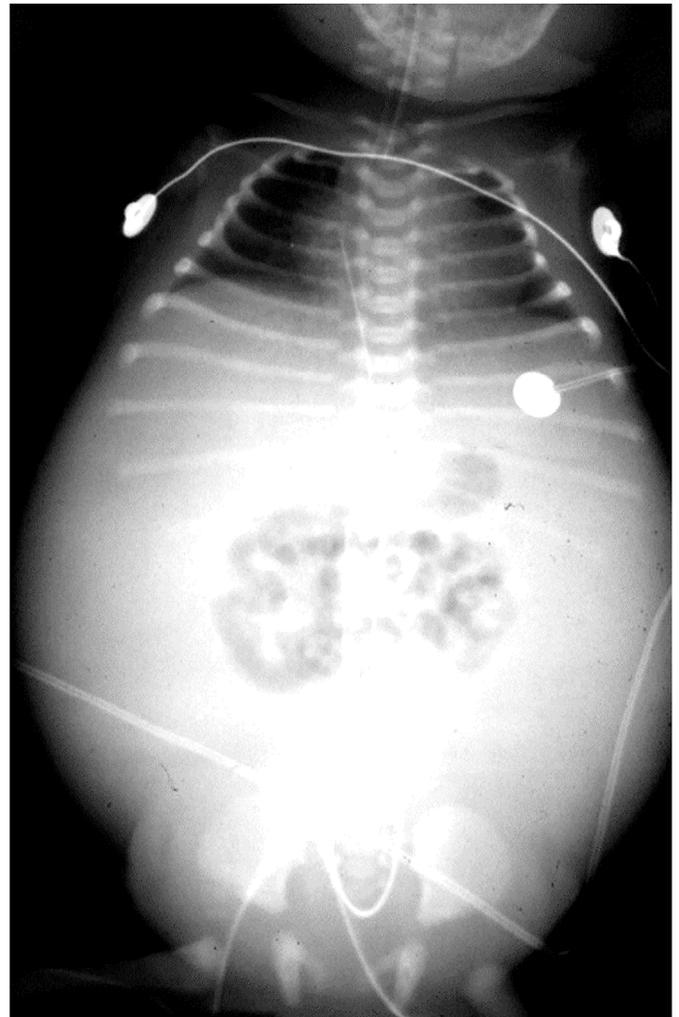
X-ray demonstrating spinal cord transection at level above C4. Newborn is intubated. Photo courtesy of: Gerardo Cabrera-Meza MD.
